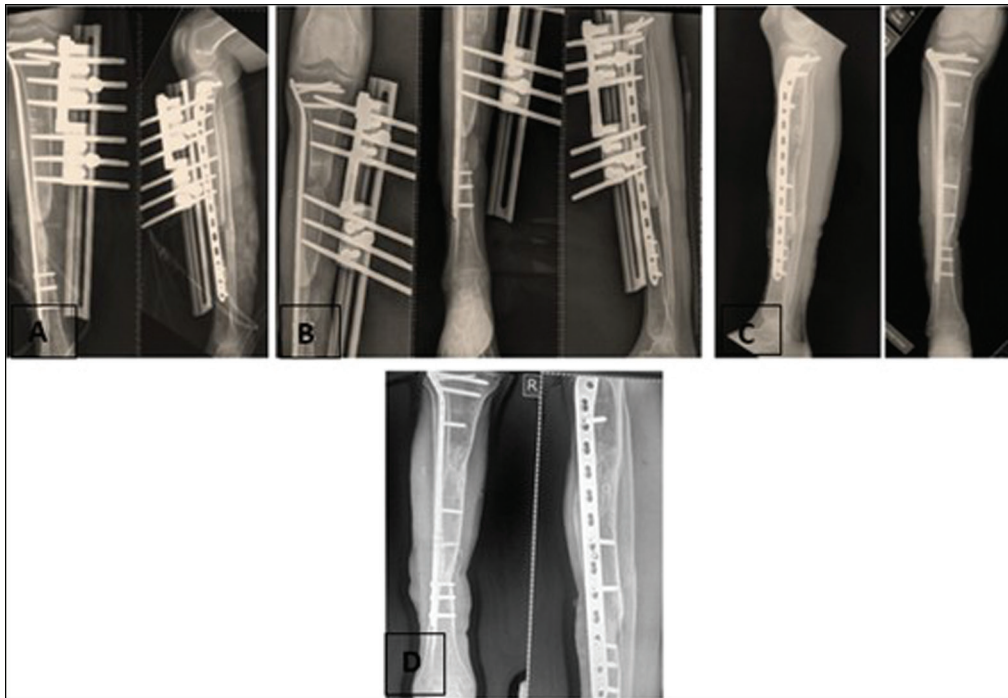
Radiographs of patient. (A) Immediate post op radiograph. (B) Radiograph after 2 weeks of distraction. (C) Radiograph after completion of distraction phase at 50 days post-op, followed by removal of LRS and Percutaneous insertion of screws in distracted segment. (D) Radiograph at the end of consolidation phase at 120 days postop
